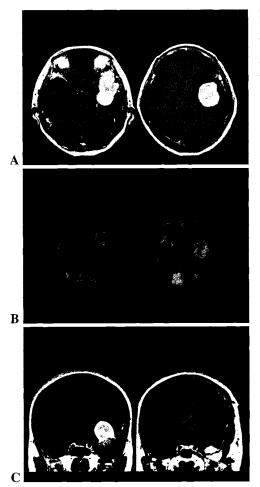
Temporal base meningioma. A MR images a homogenously enhancing tumor at the temporal base. B FDG accumulates intensely in the lesion and less in the surrounding brain. C Dumbbell-shaped meningioma is extensively eradicated trough transzygomatic approach (left: preoperative, right: postoperative). Direction of surgical axis parallel to the long axis of tumor maximizes resection of tumor and minimizes mechanical pressure to the surrounding brain during surgery
